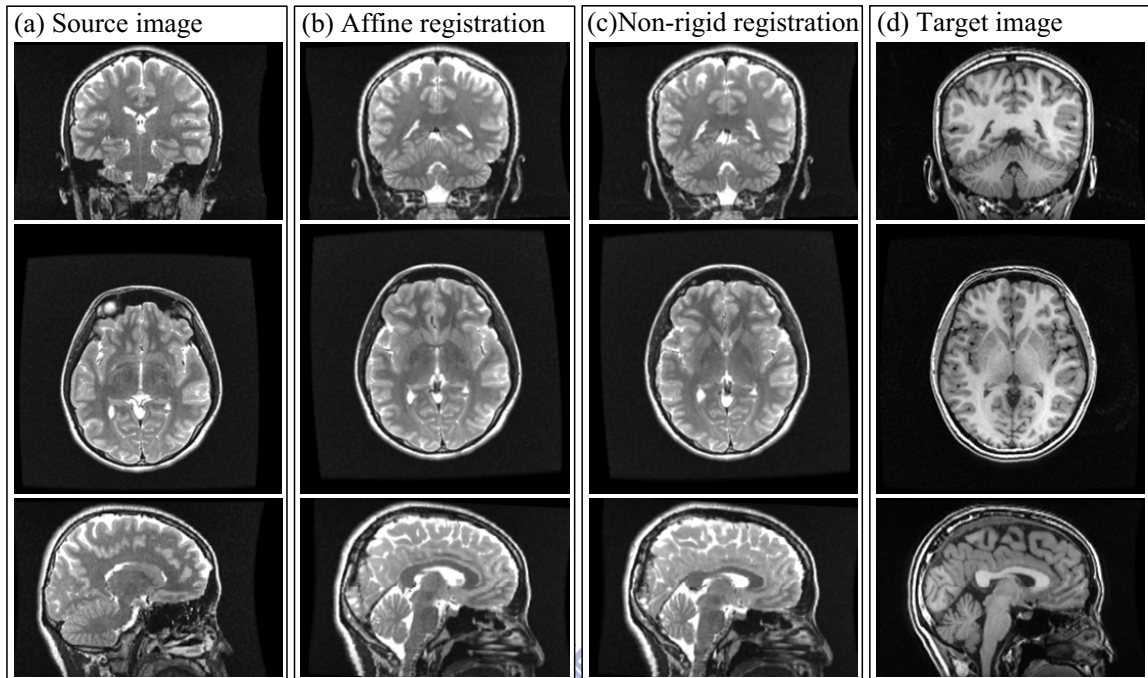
Inter-subject non-rigid alignment between T1-weighted and T2-weighted brain images using the proposed BIRT methods. (a) T2-weighted brain image as the source image. (b) Source image after the affine registration. (c) Source image after the non-rigid registration. (d) T1-weighted brain image as the target image.
